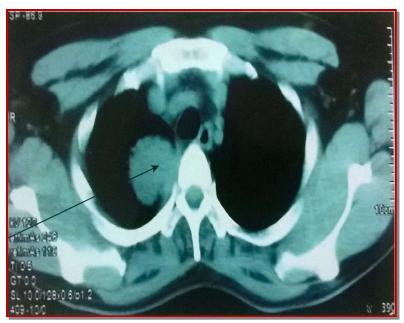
CT scan of the chest showing hyperdense mass lesion at the right upper lobe (marked by arrow)
